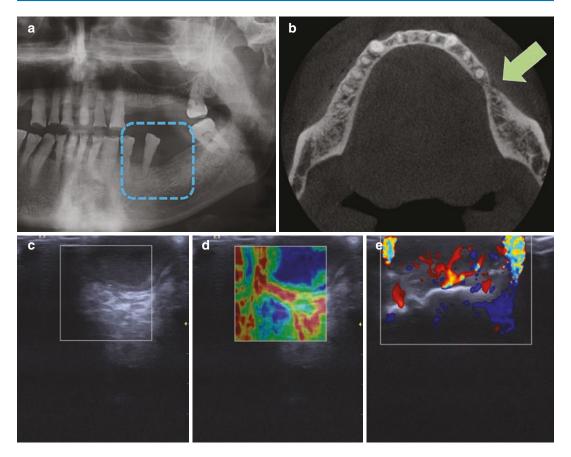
A benign soft tissue lesion in gingiva (a) on orthopantomography (mild bone loss in blue frame), (b) on axial CBCT slice (mild cortical bone loss with green
